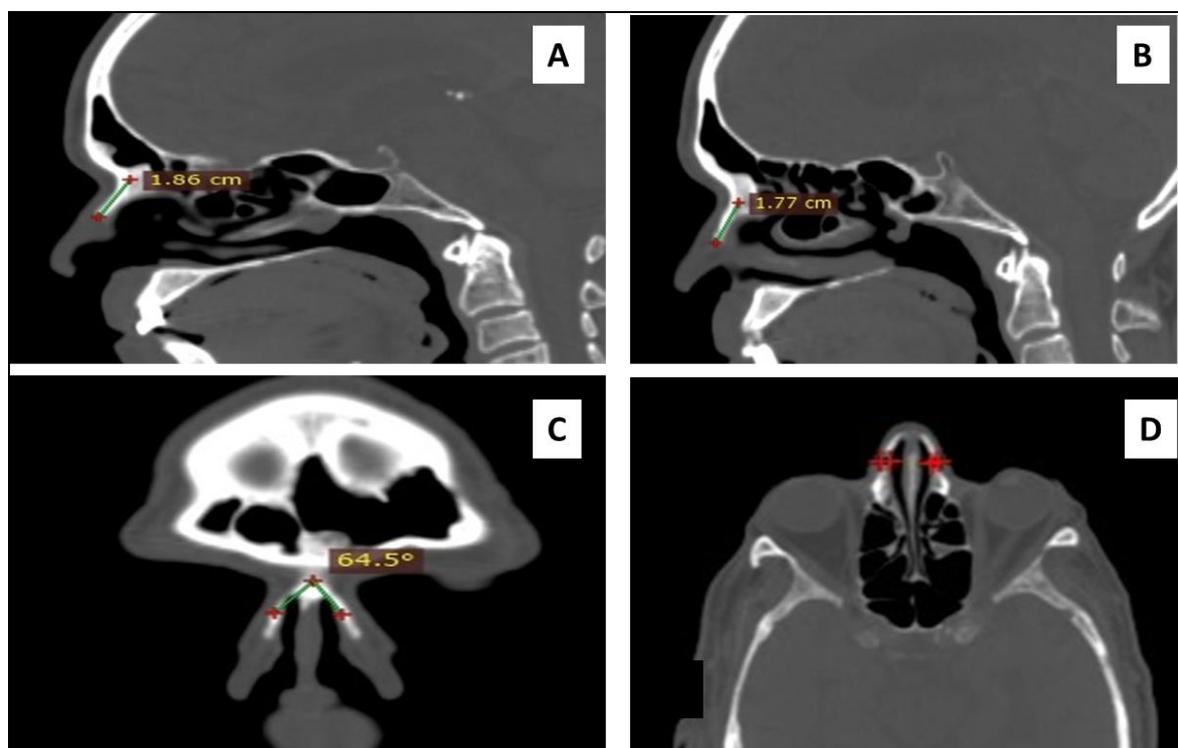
Assessment of nasal morphology with CT. A) Length of left side of nasal bone, B) length of right side of nasal bone, C) internasal angle in coronal section, D) lateral nasal bone thickness
